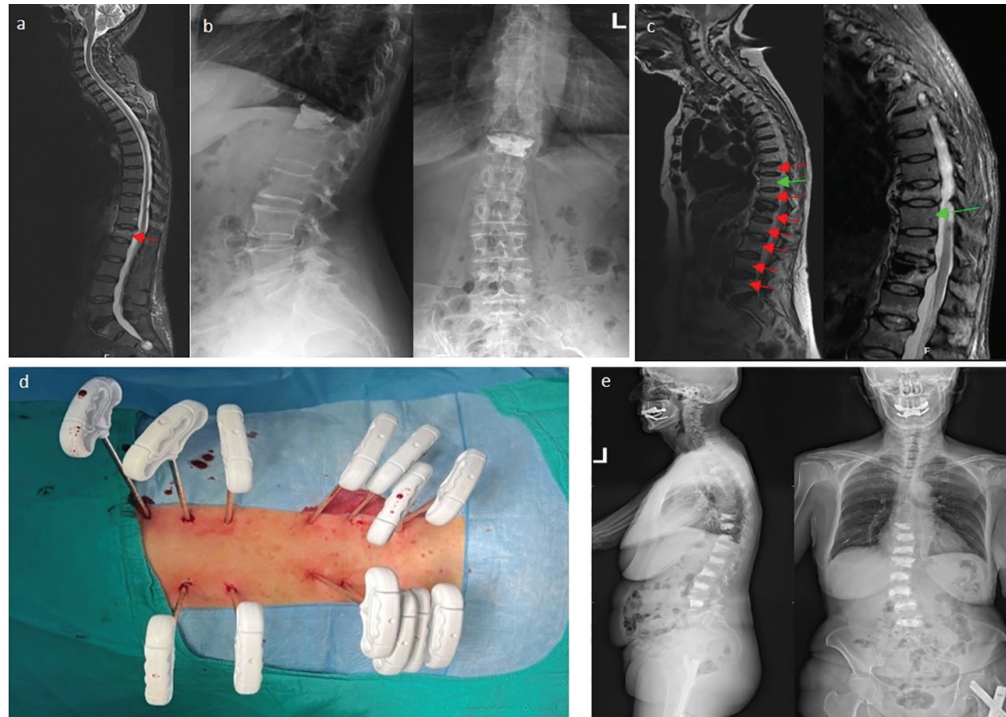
A 70-year-old female patient with a history of an L1 traumatic compression fracture treated with vertebroplasty and osteoporotic bone T-score levels presented with spontaneous acute back pain. (a) Initial pre-operative STIR-sequenced MRI images indicating an acute compression fracture at the L1 level. (b) Post-operative X-ray images after the first surgery, showing that the T12 vertebra was treated with vertebroplasty while the other vertebrae remained intact. (c) Whole-spine STIR-sequenced MRI images obtained after the onset of new back pain. Red arrows indicate newly developed multilevel compression fractures, while the green arrow highlights the intact T11 vertebral body. (d) Intraoperative multilevel single-session procedures. (e) Post-operative X-ray images, demonstrating that all fractured levels were filled with cement. Although the T11 vertebra had not collapsed, it was included in the treatment with vertebroplasty to prevent a high likelihood of fractures between the T10 and T12 vertebrae following KP
